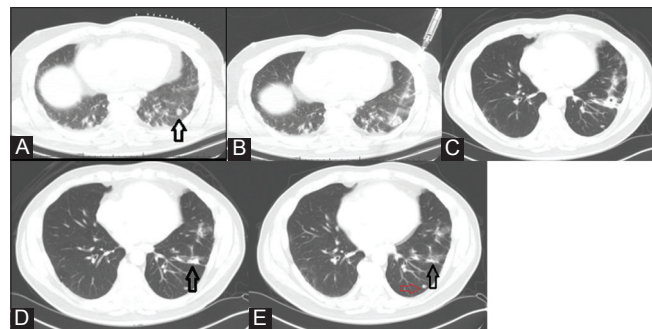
(A-E): A 55-year-old male with NSCLC. (A) CT scan (Siemens Healthcare, Knoxville, Tennessee, USA) of the chest shows a nodule measuring 1.4 × 1.4 cm in the left lower lobe (black arrow) (B) CT-guided RFA performed (Boston Scientific, Natick, MA, USA). A small area of GGO is seen developing around the nodule (C) CT 1 month later shows increase in size of the nodule as compared to pre-RFA, measuring 2.1 × 2.1 cm and showing central cavitation (D) CT 3 months later shows reduction in size of nodule to 1.5 × 1.3 cm (black arrow) (E) CT at 6 months shows further reduction in size (black arrow). Meanwhile, another nodule had developed (red arrow)
